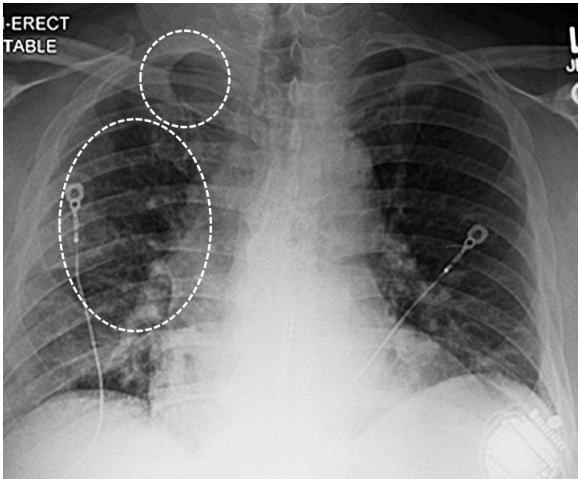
Chest X-Ray showing lung parenchyma diminished with ongoing basilar hypoaeration. Predominantly peripheral groundglass hazy opacities, worse in the right lung field (outlined by the dashed lines), are typical for induced-Covid-19 pneumonia.
